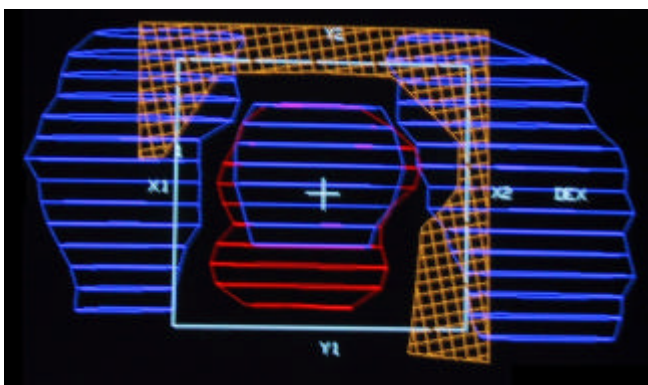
A representative coronal projection view used on the treatment planning system, showing the contours of target volumes and dose limiting organs. Laterally: critical organs (kidneys, blue color). In the middle: target volume (part of pancreas) as identified by CT alone (blue) and as identified by combined CT/PET (red); irradiation field (white box); wedges used to limit dose to critical organs (orange grid).
